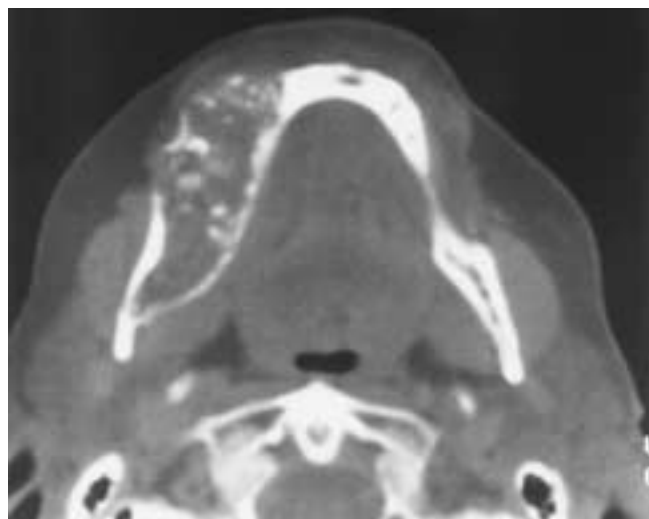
Pindborg tumor. Axial CT (bone window setting) shows marked expansion of the right mandible with loss of bone in the lateral cortex. Multiple calcific densities are noted within the lesion.
